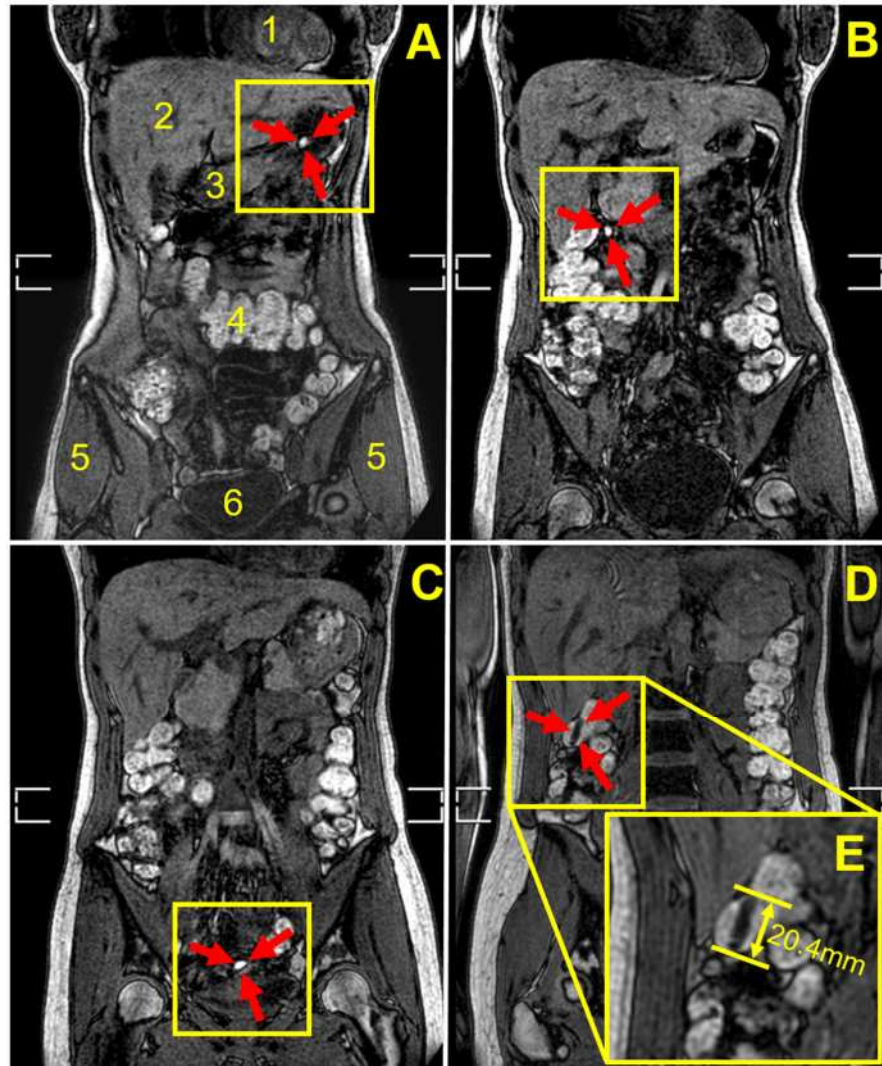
Coronal, fat and water out of phase MRI images of the abdomen of participant number 2 after consumption of the coated capsule co-administered with 240 mL of water. Anatomical landmarks are indicated in (A) by numbered labels as heart (1), liver (2), stomach antrum (3), transverse colon (4), gluteus medius muscle (5) and bladder (6). The white brackets at the side of the body derive from the fusion of the two separate breath-hold image stacks acquired. The filled capsule appears bright. It was located intact and floating in the body of the stomach 45 min after consumption as shown in panel (A) indicated by the red arrows inside the yellow box. The capsule was detected later in the small bowel in the duodenum 90 min (B) and ileum (C) 135 min after consumption. Finally, the capsule was located in the large intestine in the ascending colon, near the hepatic flexure, 180 min after consumption (D). By this time the capsule appeared to be empty of oil but still with an almost complete capsule shape, visible in (D) as a dark spherocylindrical object that measured 20.4 mm length (inset E). The white brackets at the side of the body derive from the fusion of the two separate breath-hold image stacks acquired.
